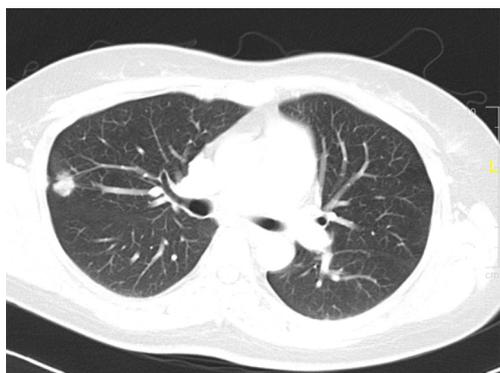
CT scan of patient who underwent first UVATS lobectomy for lung cancer. UVATS, uniportal video-assisted thoracic surgery.
